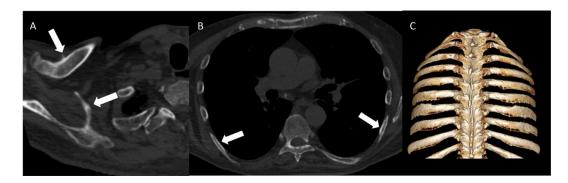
Unenhanced chest CT Axial image 7 months after discontinuation of voriconazole. Axial images (A, B) and 3D reconstruction (C) demonstrate significant interval reduction in periosteal reaction previously seen along the clavicle, scapula and bilateral mid posterior ribs (arrows).
